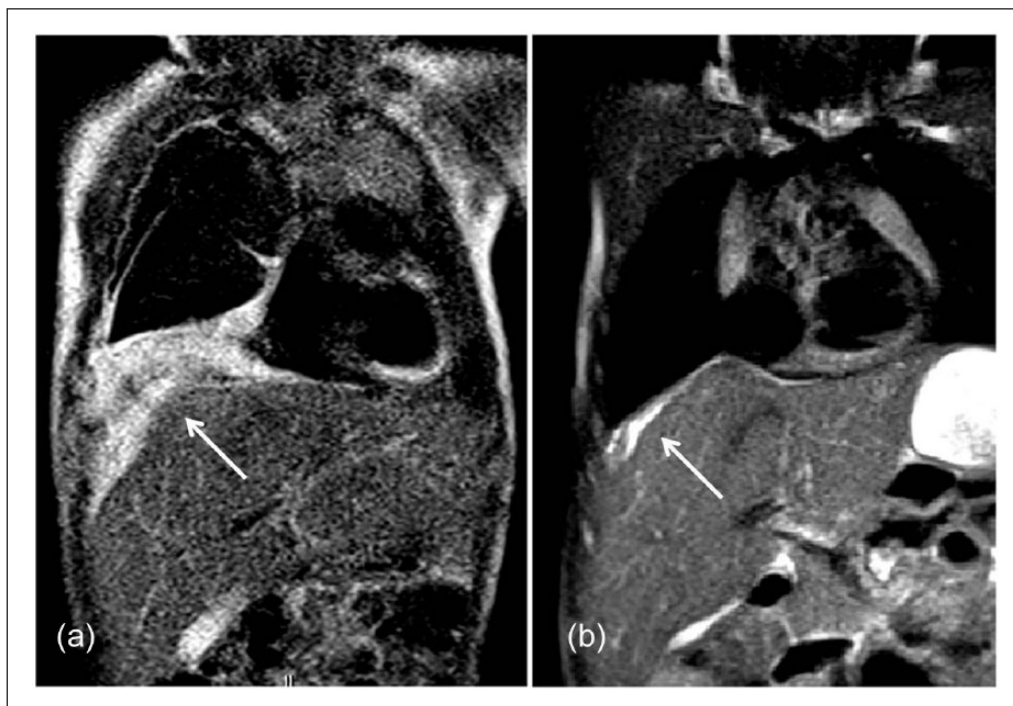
MRI shows the right diaphragmatic hemangioma. (a) The right diaphragmatic hemangioma shows a pattern of intense hyperintensity on T₂-weighted image (arrow). (b) The follow-up MRI examination at 18 months confirms the tremendous regression of the hemangioma (arrow) and the disappearance of pleural effusion.
